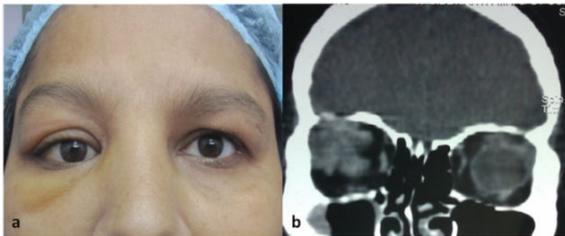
a: Clinical photograph showing fullness in right lacrimal gland region with inferior dystopia of eyeball. b: CT scan showing an irregular mass with diffuse enhancement in lacrimal gland fossa associated with erosion of roof of the orbit and no intracranial extension.
